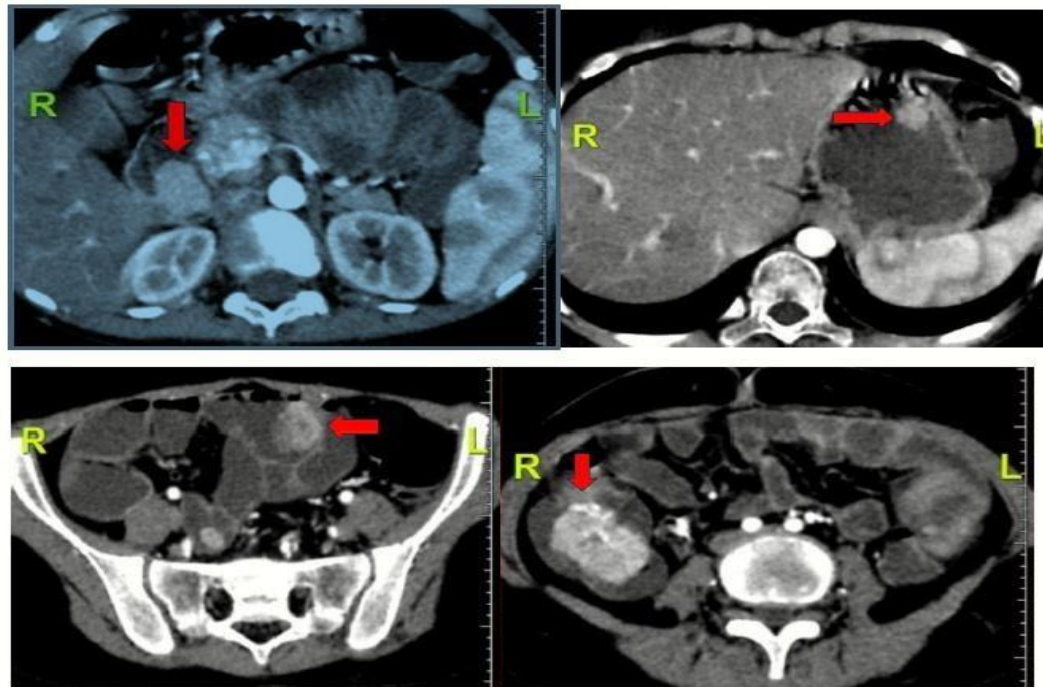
Axial contrast-enhanced CT Abdomen images (arrows) arising from the wall noted in stomach, duodenum, showing Multiple well-defined enhancing lesions (red jejunum, ileal loops and the ascending colon).
